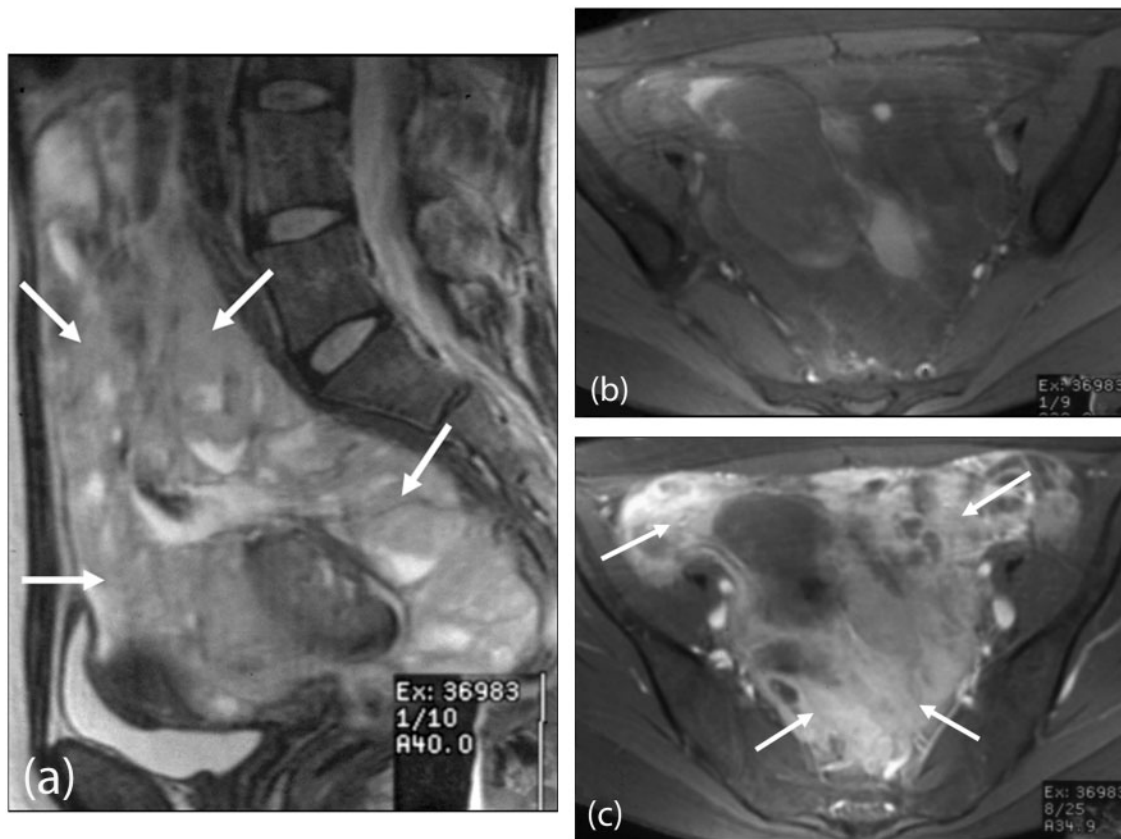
Desmoplastic small round cell tumour. MRI pelvis (a) sagittal T2-weighted and (b) axial T1-weighted images demonstrating a large lobulated peritoneal mass extending into the pelvis (arrows), which shows (c) enhancement after intravenous gadolinium injection (arrows).
